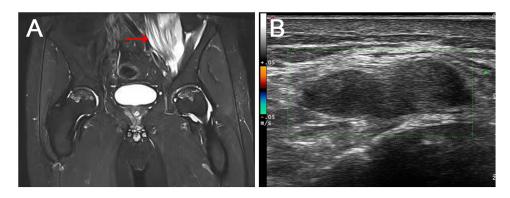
Figure I Magnetic resonance imaging results. (A) Magnetic resonance imaging revealed the abscess in left psoas, gluteus maximus and iliac muscles (red arrow indicated), intermuscular encapsulated effusion, as well as enlarged lymph nodes in the left inguinal region. (B) Color Doppler ultrasound revealed a honeycomb, hypoechoic area in left Hip.
